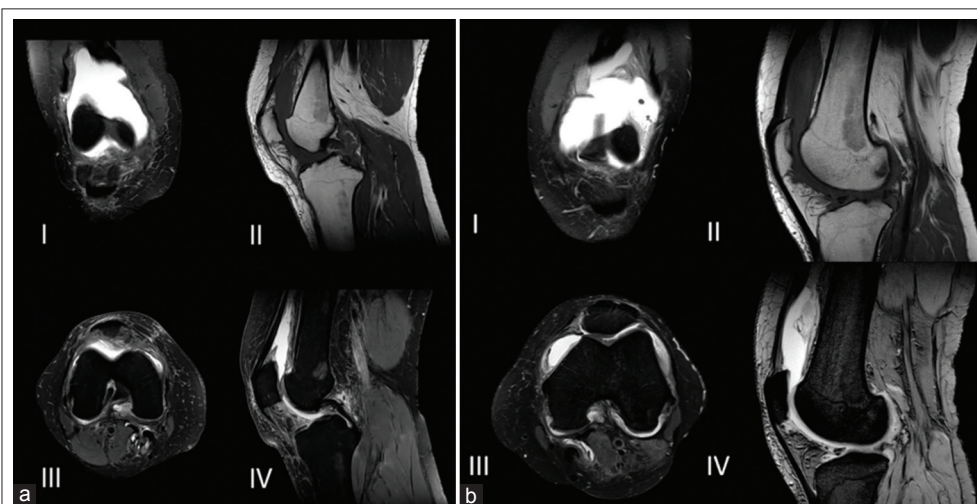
(a and b) Magnetic resonance imaging findings at the last follow-up ([a] right knee I: EPDW_SPIR coronal, II: ET1W_TSE sagittal; III: EPDW_SPAIR axial, and IV: EPDW_SPAIR sagittal; [b] left knee I: EPDW_SPIR coronal, II: ET1W_TSE sagittal; III: EPDW_SPAIR axial, and IV: EPDW_SPAIR sagittal): Post-operative complete ablation of the papillary formations; persistence of bone marrow reconversion.
